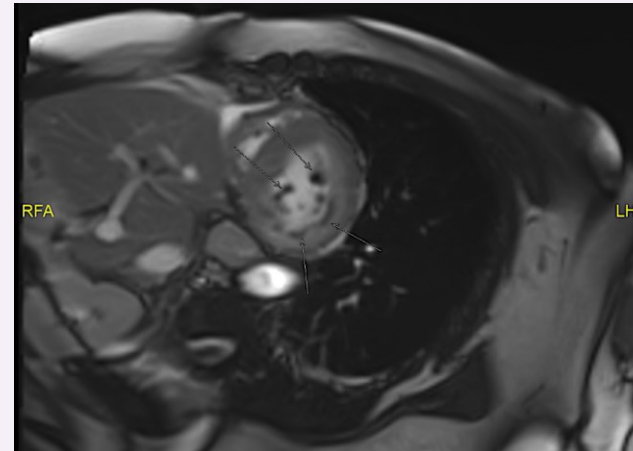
Cardiac MRI showing diffuse subendocardial hypoperfusion and delayed enhancement in multiple vascular territories involving the left ventricular wall and papillary muscles.
